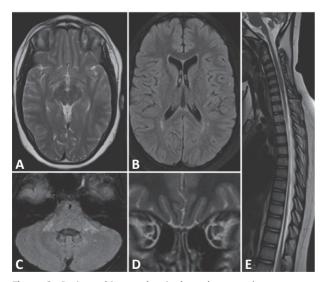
Brain, orbits, and spinal cord magnetic resonance imaging showing the recovery of the lesions. (a) Axial T2. Diencephalic lesions. (b) Axial fluid-attenuated inversion recovery. Bihemispheric white matter and corpus callosum. (c) Axial fluid-attenuated inversion recovery. Middle cerebellar peduncles and around the fourth ventricle. (d) Coronal T2. Bilateral optic nerve without hypersignal. (e) Sagittal T2. Reduction of epidural lipomatosis, although still evidencing the dorsal segment. Marked atrophy of the spinal cord, mainly from C6 to the medullary cone where it is filiform.
